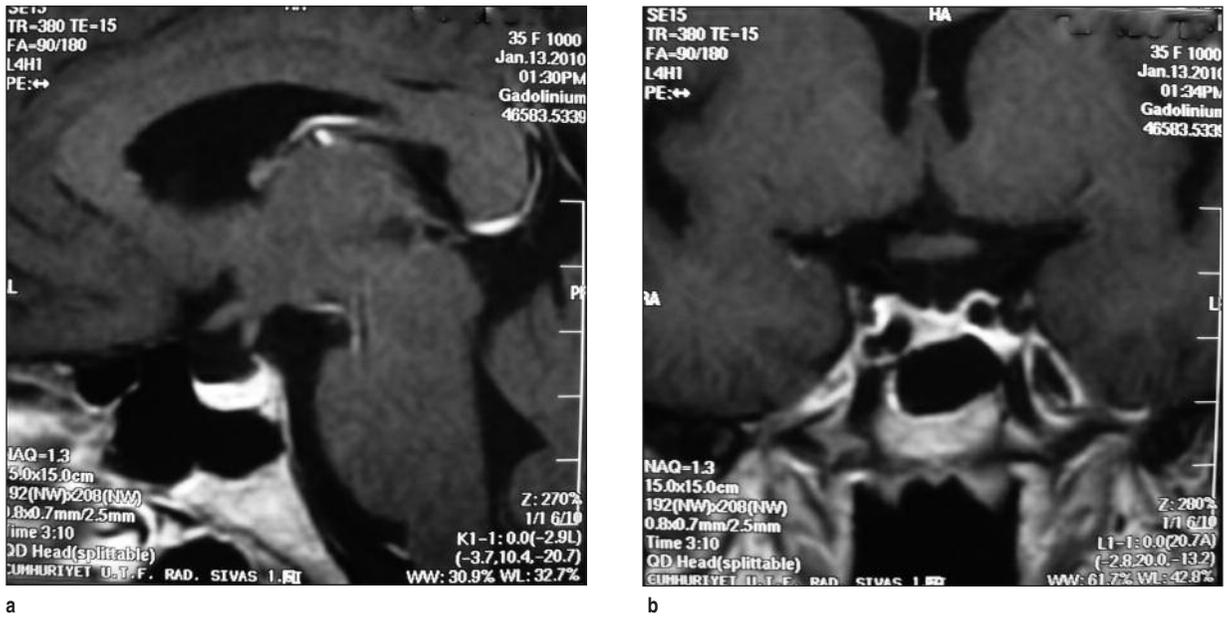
Posttreatment magnetic resonance imaging (MRI) of the pituitary stalk.
